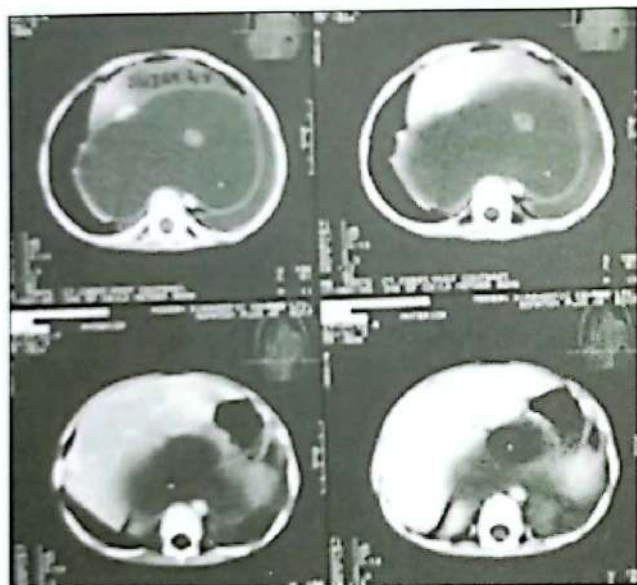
CT Scan of chest showing mediastinal cystic mass lesion.
